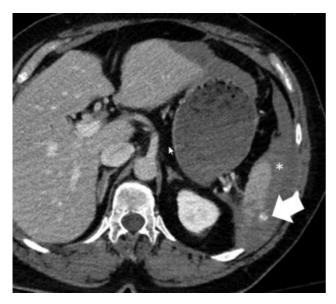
Axial slice from a contrast-enhanced CT obtained after a motor vehicle collision demonstrates a splenic laceration with contrast extravasation from the spleen (white arrow) and associated hemoperitoneum (asterisk).
